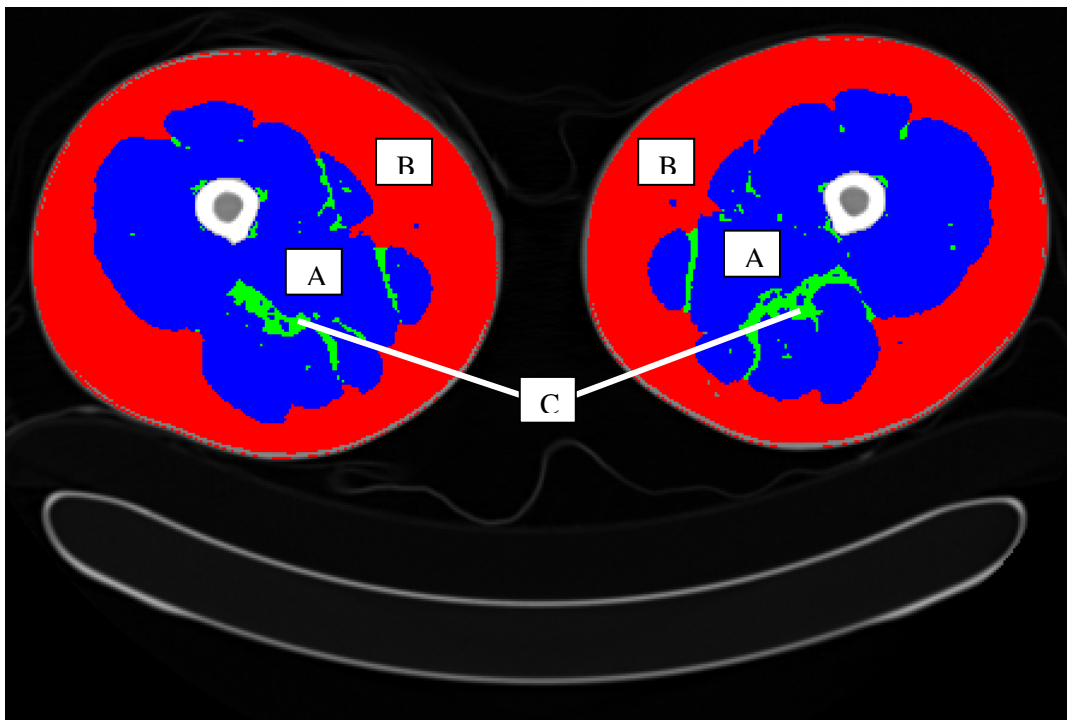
Axial plane of both thighs on a typical resolution CT scan. (A) Skeletal muscle tissue; (B) Subcutaneous adipose tissue; (C) Intermuscular adipose tissue.
